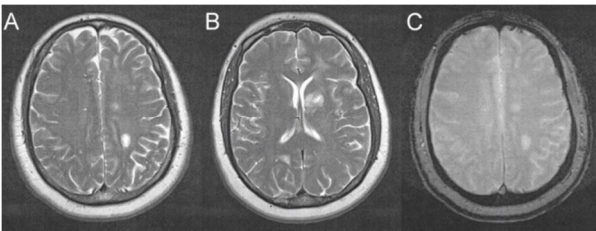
MRI of brain (3 month after initial scans) showing axial T-2 weighted (A-B) hyperdense lesions of the left centrum semiovale(A) and left basal ganglia(B). There is irregular peripheral enhancement. Considerable decrease in size is seen from previous MRI (Figure 2). Left posterior centrum semiovale, left globus pallidus and left occipital lobe lesion measure 1.3 cm, <1 cm and <1 cm respectively. Vasogenic edema is diminished in comparison to previous study.
